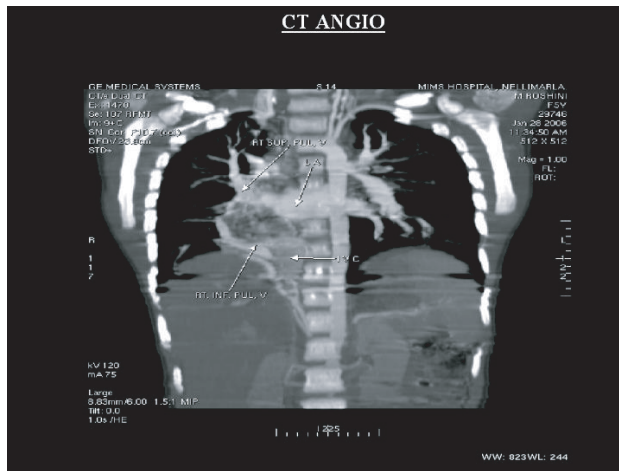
CT angio showing right lower lobe vein (scimitar vein) draining to I.V.C.
